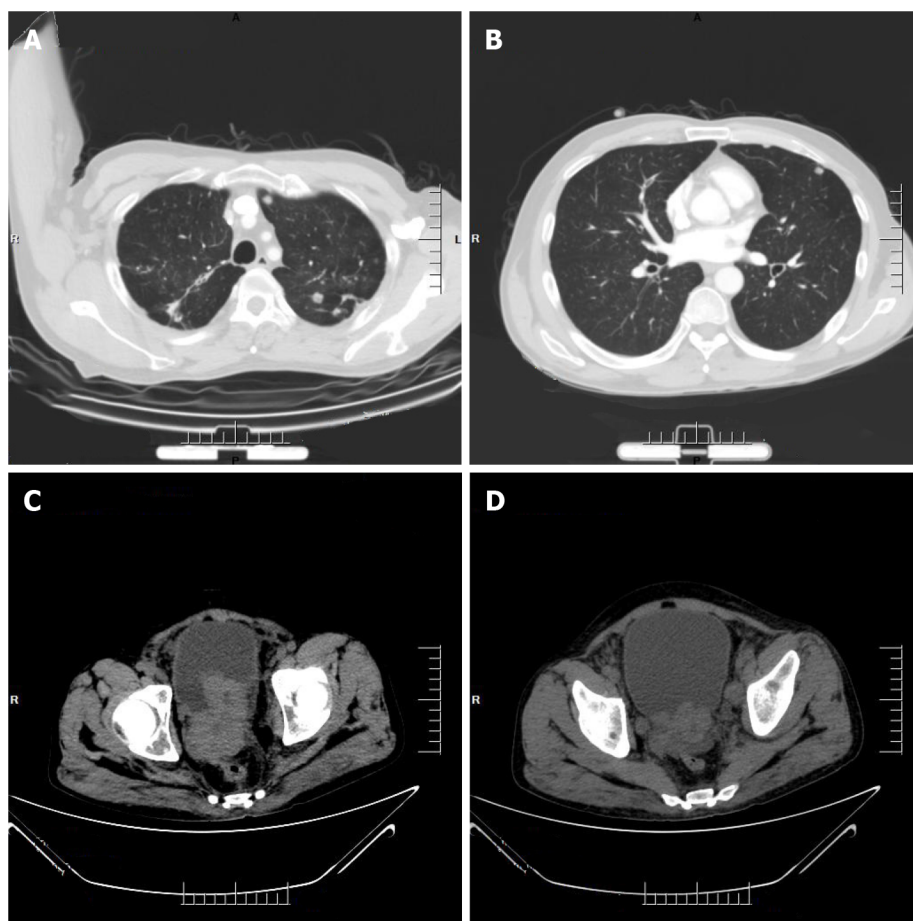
Computed tomography. A and B: Computed tomography (CT) imaging of the lung: Multiple nodular shadows in both lungs, with possible Small-cell carcinoma of the prostate metastases; C and D: CT imaging of the abdomen: An irregular enlargement of Small-cell carcinoma of the prostate showing a tendency to infiltrate, bilateral involvement of the inner segment of the ureteral bladder wall, dilatation and fluid retention in the urinary tract, and multiple bone destruction in the pelvis.
